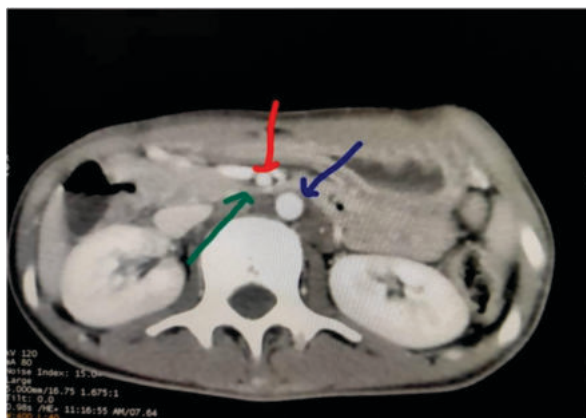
Contrast enhanced computed tomography of the abdomen in venous phase showing compression of third part of the duodenum between superior mesenteric artery and aorta. Blue arrow- aorta, red arrow – superior mesenteric artery, Green arrow – 3rd part of duodenum
